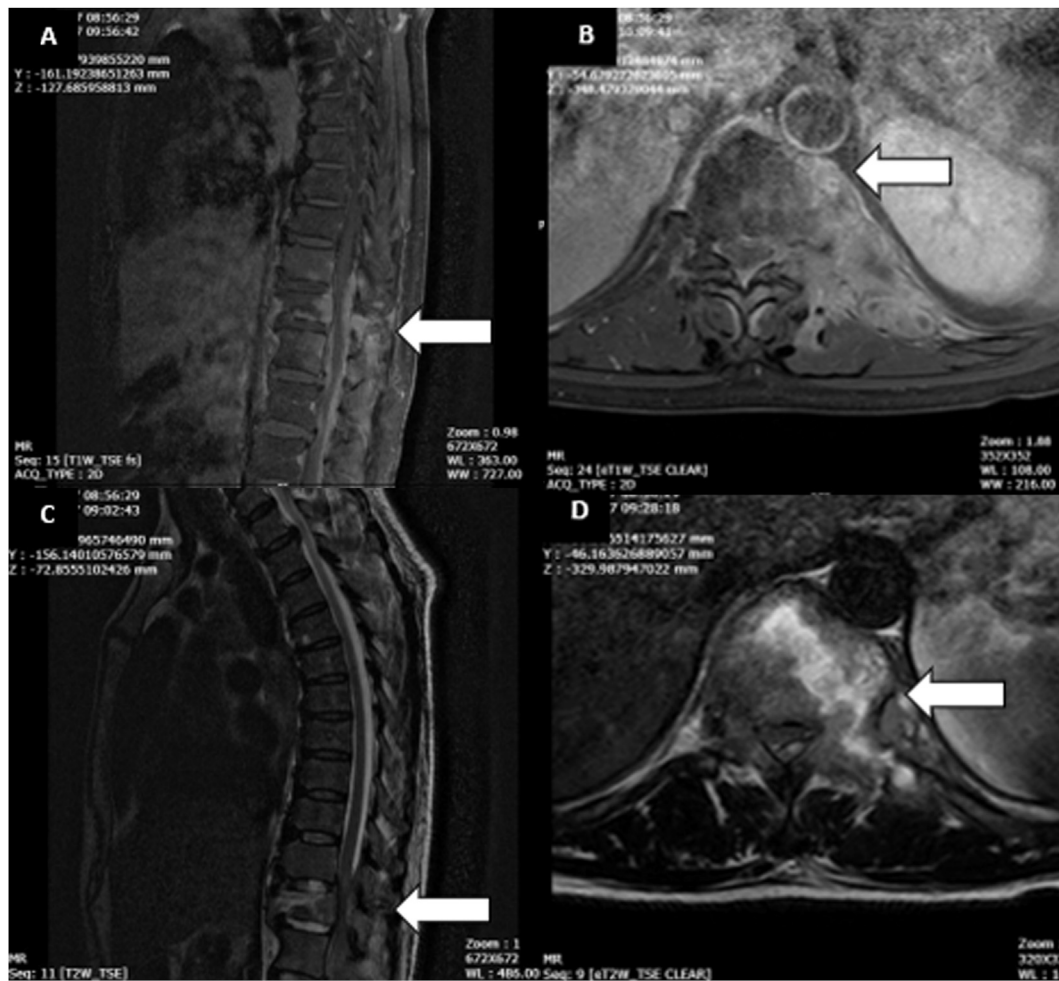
A. Magnetic Resonance T1-weighted sagittal image. B. T1-weighted axial image. C. T2-weighted sagittal image. D. T2-weighted axial image. Arrows show the lesion site.
